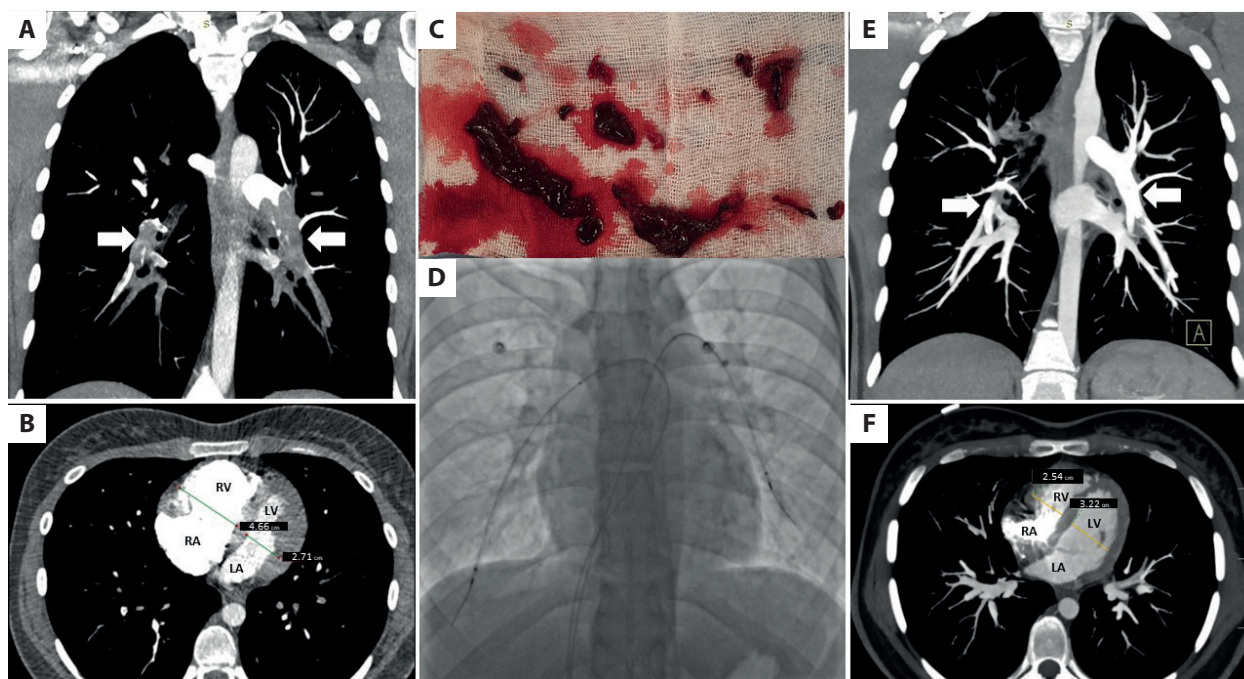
A. Angio CT of a 16-year-old girl with sudden syncope, dyspnea, and chest discomfort confirming the diagnosis of pulmonary embolism with massive proximal clots in both PAs (arrows). B. Angio CT showing dilation of the RV and the RV-to-LV ratio of 1.7; no thickening of the RV wall is present. C. Clots evacuated from PAs with the PENUMBRA Lightning 12 system during catheter-directed thrombolectomy procedure based on the Pulmonary Embolism Response Team's decision as no significant clinical improvement could be reached despite therapeutic anticoagulation, which led to a mPAP reduction from 34 to 32 mm Hg and CI improvement from 1.48 to 1.58 l/min/m² as assessed by right heart catheterization. D. Fluoroscopy showing infusion catheters placed within remaining clots in both PAs for low-dose catheter-directed thrombolysis, with a total dose of 20 mg delivered during 10 hours and resulting in a further mPAP reduction to 21 mm Hg and CI increase to 2.38 l/min/m². E. Angio CT presenting treatment results with a reduction of clot burden in both PAs (arrows) and improvement in the RV/LV ratio to 0.78 (F)
